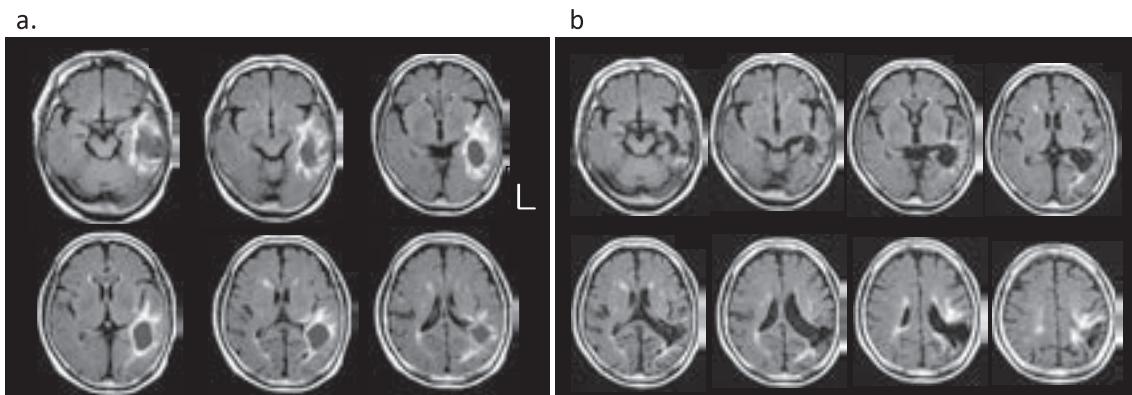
Head magnetic resonance image at 4 days and 6 months after subcortical hemorrhage in the left temporal lobe
